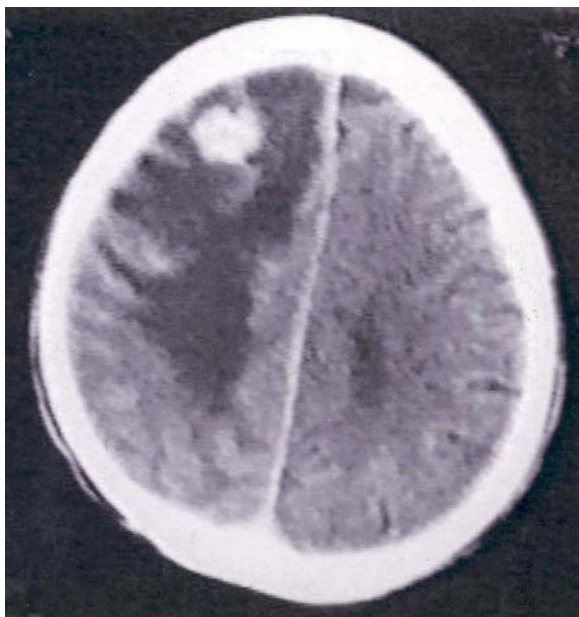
A CT scan of the brain after administration of intravenous contrast material showing one of the contrast enhanced lesions in the right frontal lobe, with surrounding vasogenic edema.
